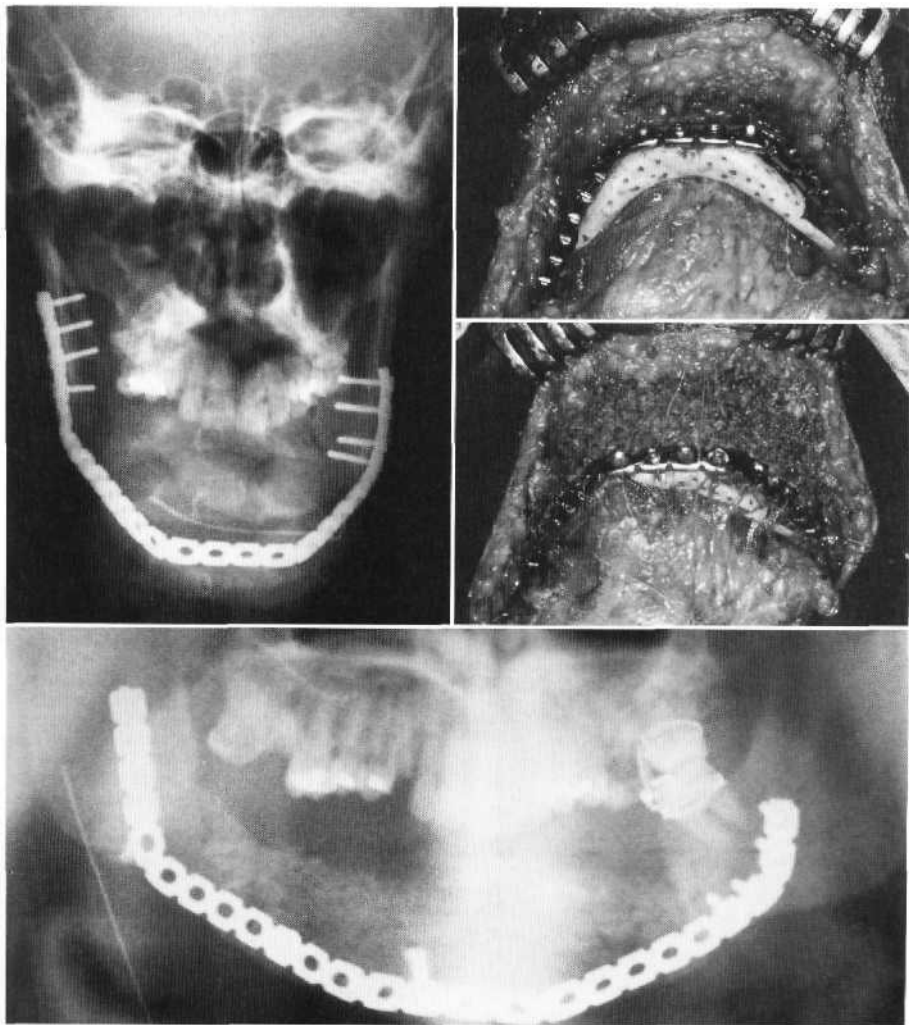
cont'd C, Full-face panoramic frontal radiograph. H, After healing of the intraoral soft tissues, an extraoral approach is used for bone graft reconstruction. An allogeneic mandible is hollowed out and secured to the bone plate with bone screws. Note the perforations of the mandible to promote revascularization. I, Particulate marrow and cancellous bone is packed within the allogeneic mandible before closure. J, Panoramic radiograph showing bone graft in place. The bone plate is left in situ.
